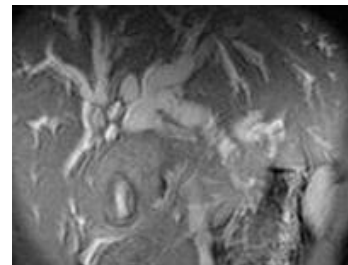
MRI - GB Carcinoma with biliary obstruction.
